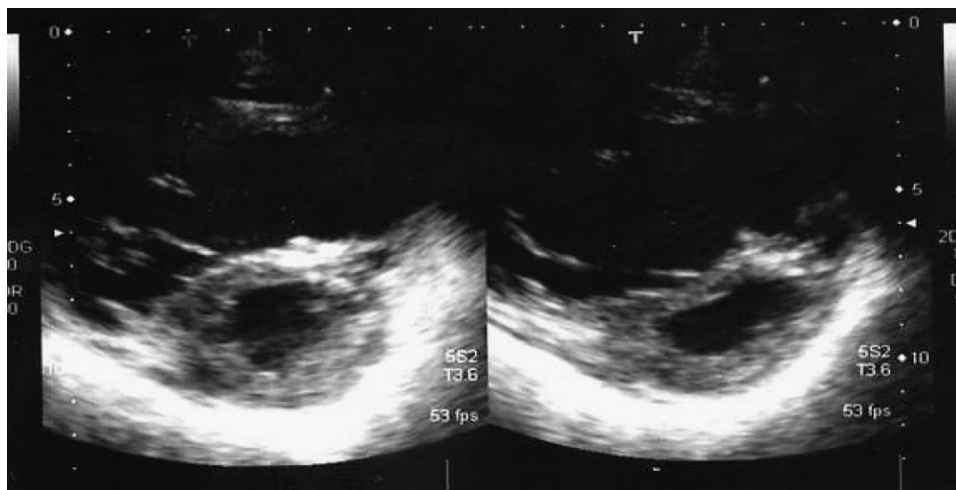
Echocardiography showed right heart loading.
